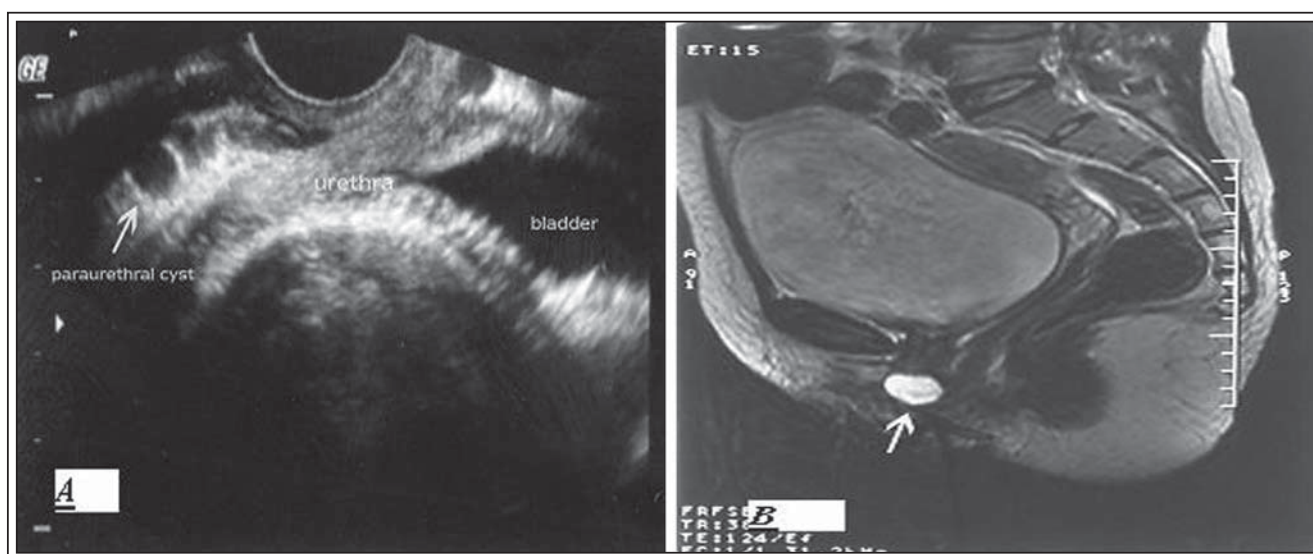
TVUS and MRI are showing paraurethral cyst does not communicate with the urethra.
